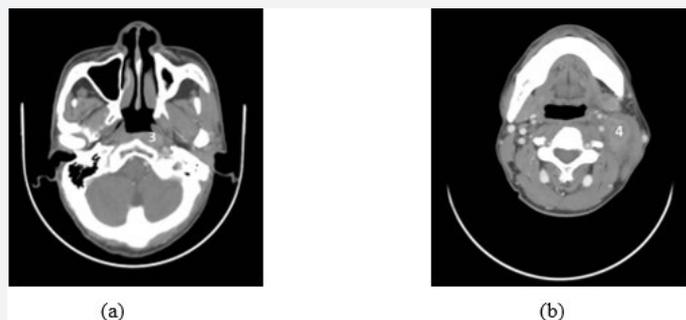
Post-treatment enhanced CT image of NPC: (a) lesion with intense enhancement (showed at number 3); (b) lymph node metastasis at level II.
